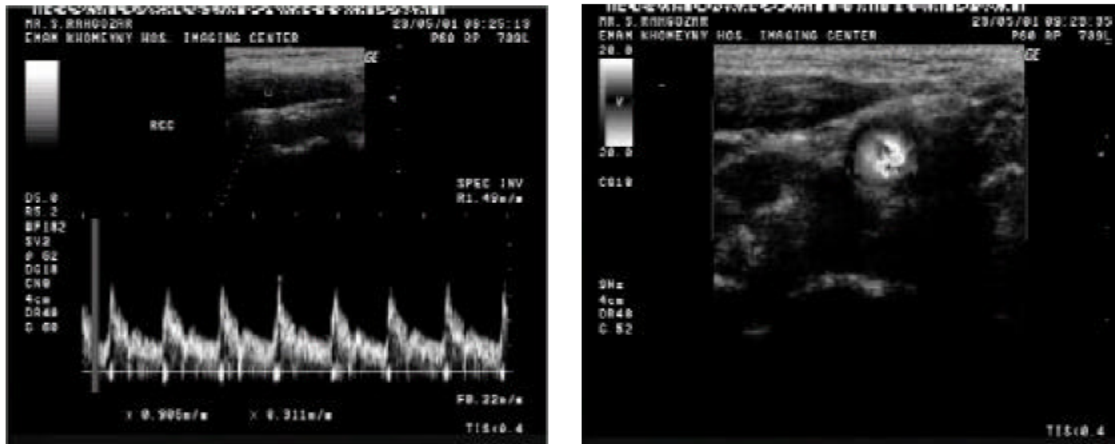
Clinical data is obtained by ultrasonic device (GE logic 500MD)
